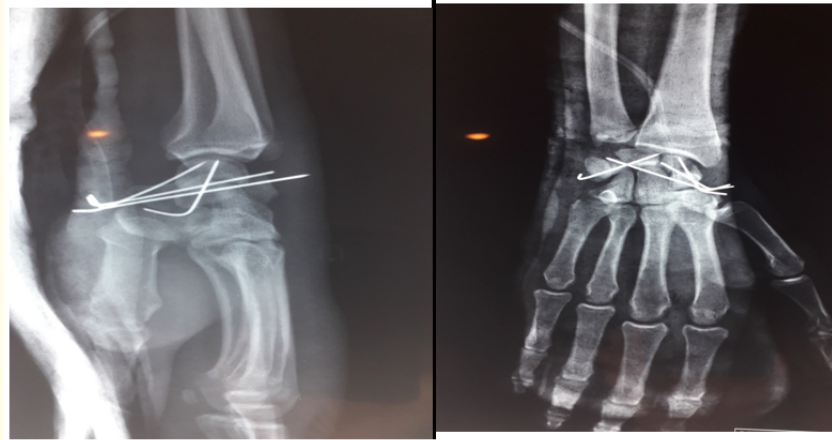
Early post operative radiograph.
